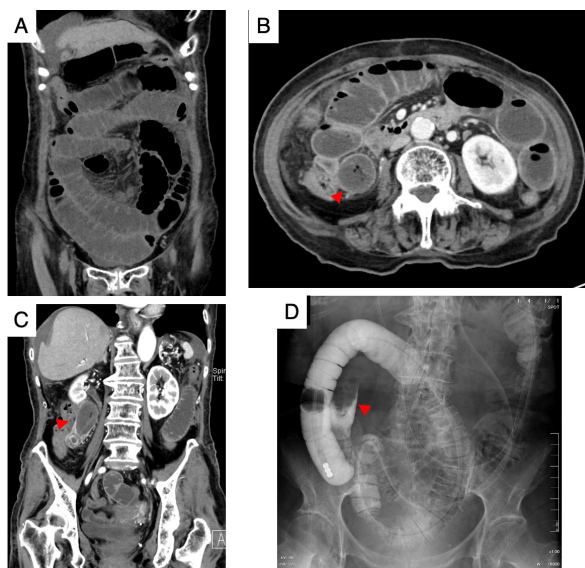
Findings from an imaging study. (A) Computed tomography scan reveals a small bowel obstruction. (B, C) Enhanced computed tomography reveals a foreign body obstructing the small bowel (red arrowhead). (D) Contrast examination revealed a foreign body obstructing the intestinal tract at the ileus tube's end (red arrowhead).
